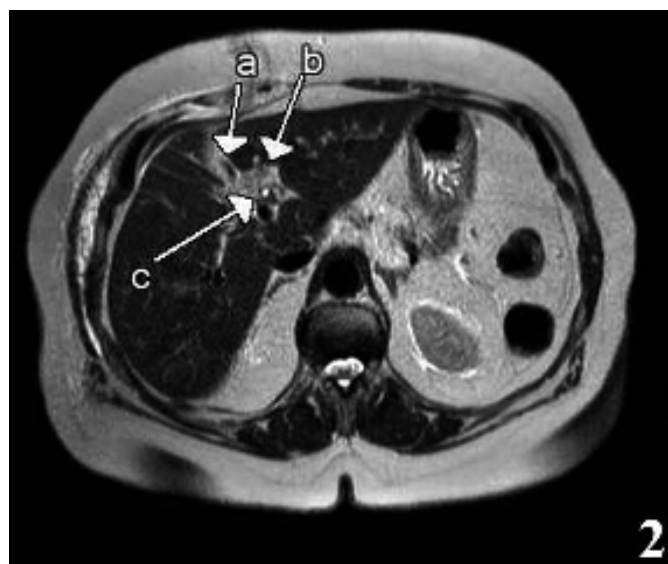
Axial T2-weighted MR showing the gallbladder bed (b) lying on the left of the falciform ligament (a) and the CD (c).
